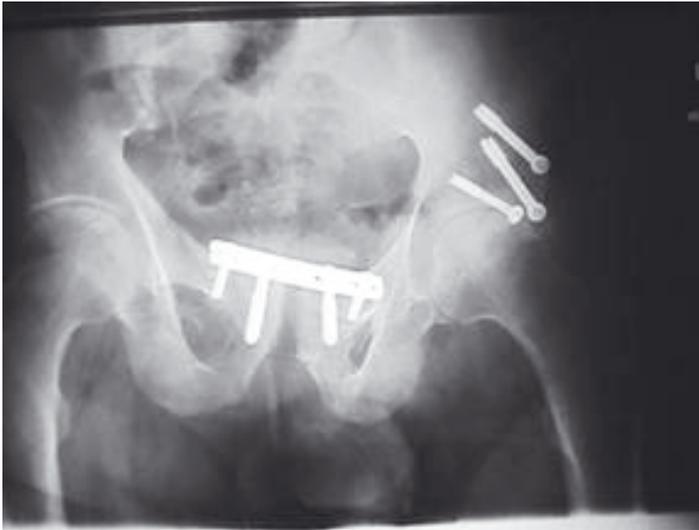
X-ray (8 months after initial trauma) showing a) Loosening of the plate osteosynthesis scan
